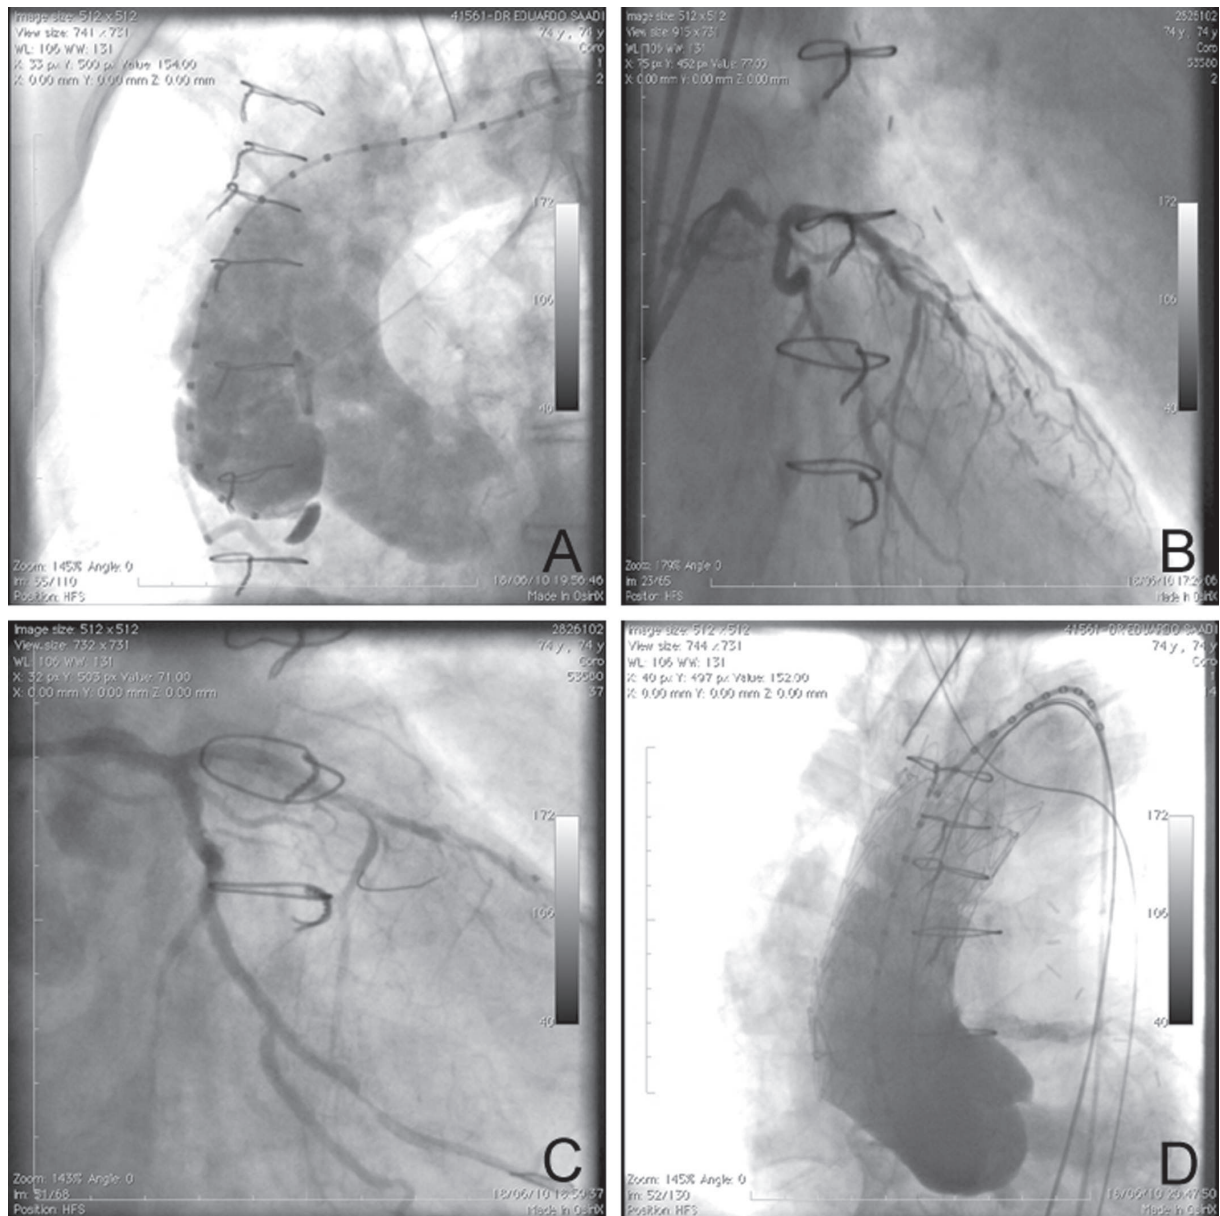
A: Pseudoaneurysm of ascending aorta. B: RCA lesions. C: Three stents implanted in RCA. D: Postoperative CT shows that three stents and two extension cuffs are well positioned. CT: computed tomography, RCA: right coronary artery
